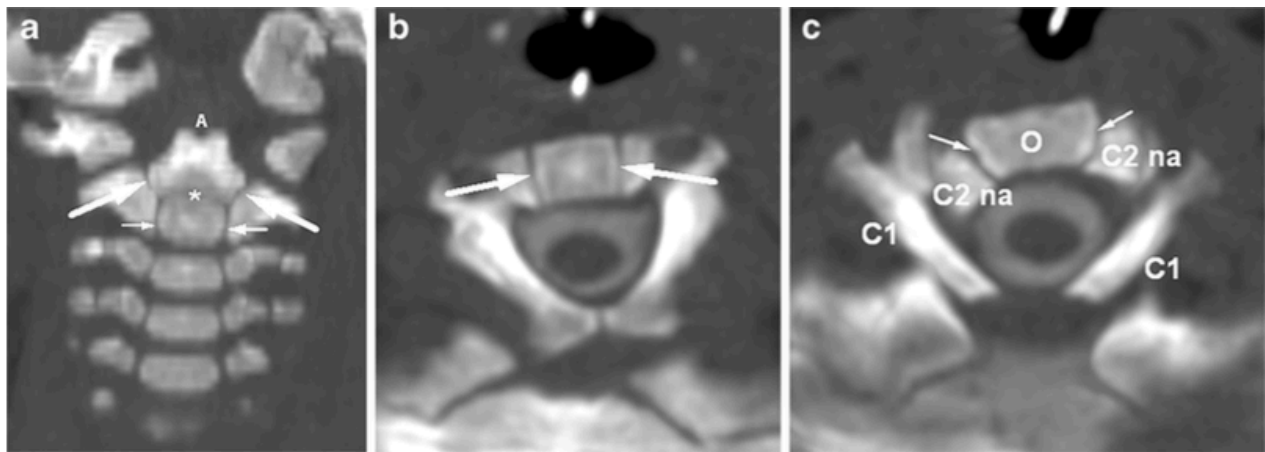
Normal synchondroses. (a) Coronal (image taken from anterior to posterior or “front” position) Computed Tomography (CT) in a 12-month-old boy and (b, c) axial (image taken from proximal to distal or “aerial” position) CT images from a CT myelogram (includes contrast dye injected into patient) in 6-month-old boy show normal immature C2 anatomy with unfused synchondroses. The five central C2 synchondroses—bilateral neurocentral (small arrows), bilateral odontoneural (large arrows) and the single transverse odontocentral synchondrosis (*)—are all open. The apicodental synchondrosis (A) is also open and os odontoideum has not yet ossified, or fused. C2 neural arches (C2 na) and C1 lamina (C1) are labeled for reference.
